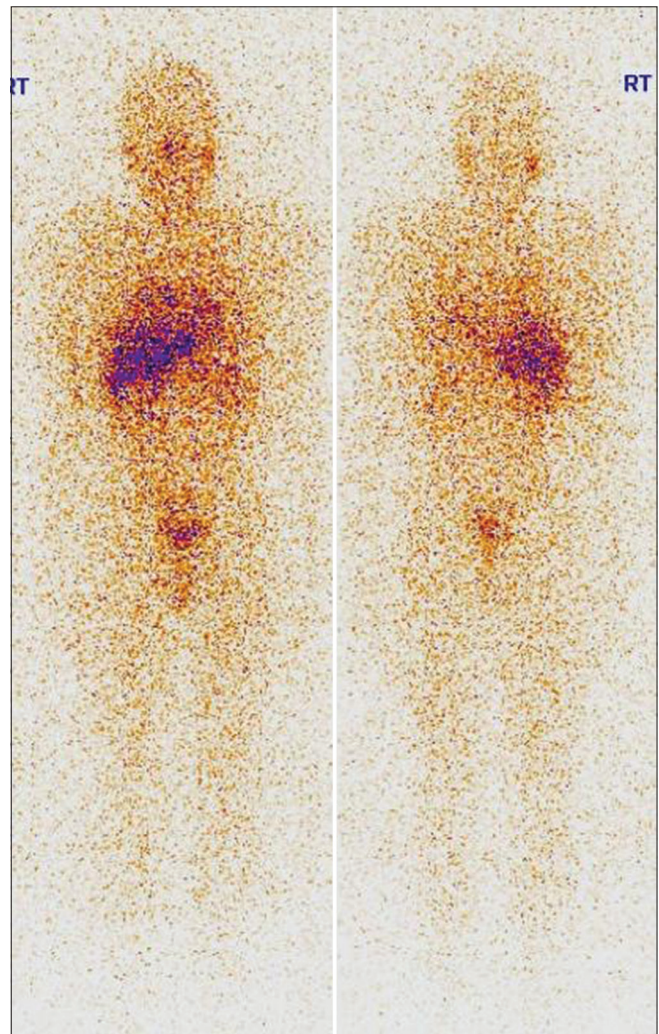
I-131 MIBG scintigraphy showing no residual disease in the retroperitoneum. Physiological uptake is noted in salivary glands, liver and bladder
